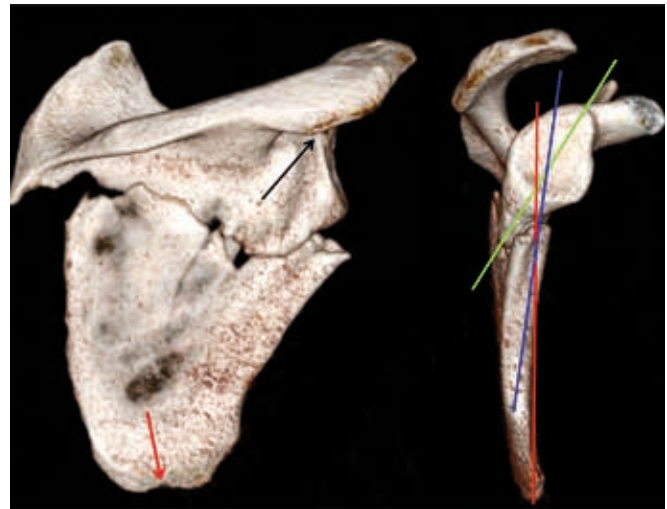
Problematic identification of metric points. In certain scapulae it is difficult to determine exactly the tip of the inferior angle (red arrow), and/or the superior pole of the glenoid (black arrow), which is often overshadowed by scapular processes on 3D CT reconstructions. In certain cases, it is difficult to determine exactly also the axis of the distal fragment of the lateral pillar.
